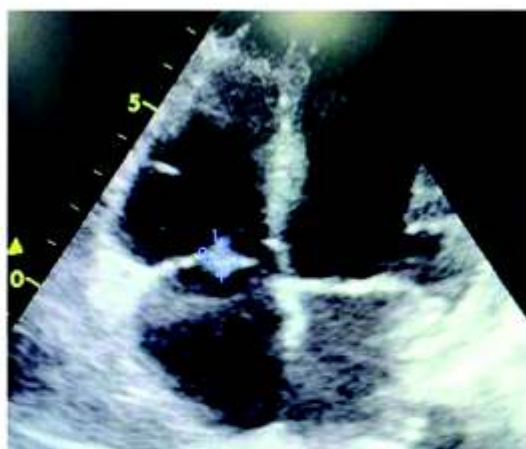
Figure showing the echocardiographic imaging of the vegetation on tricuspid valve
